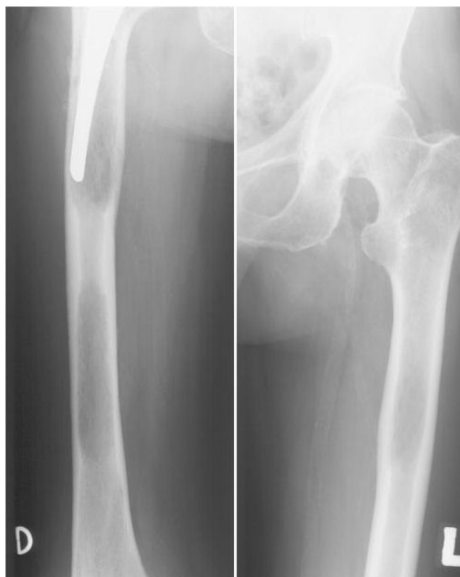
Initial radiological imaging and bone scintigraphy revealed pathologic fracture of neck of right femoral bone and diaphyseal infiltrations in both femoral bones and right humerus.
